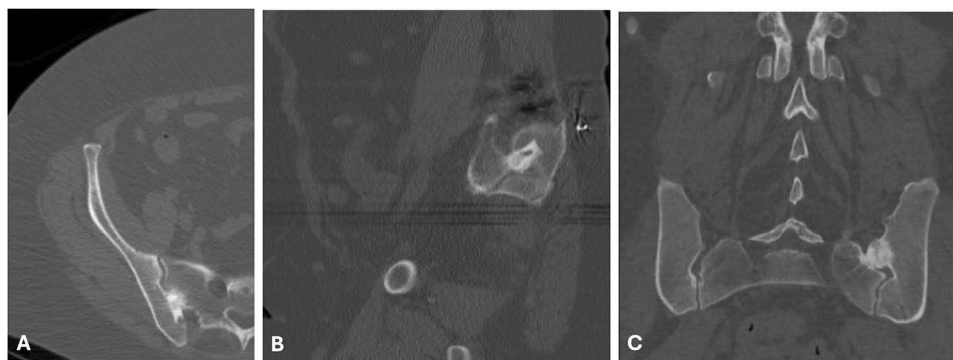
12 Month CT imaging of SIJ fusion with cortical allograft insert. (A) Axial view. (B) Sagittal view. (C) Coronal view.
